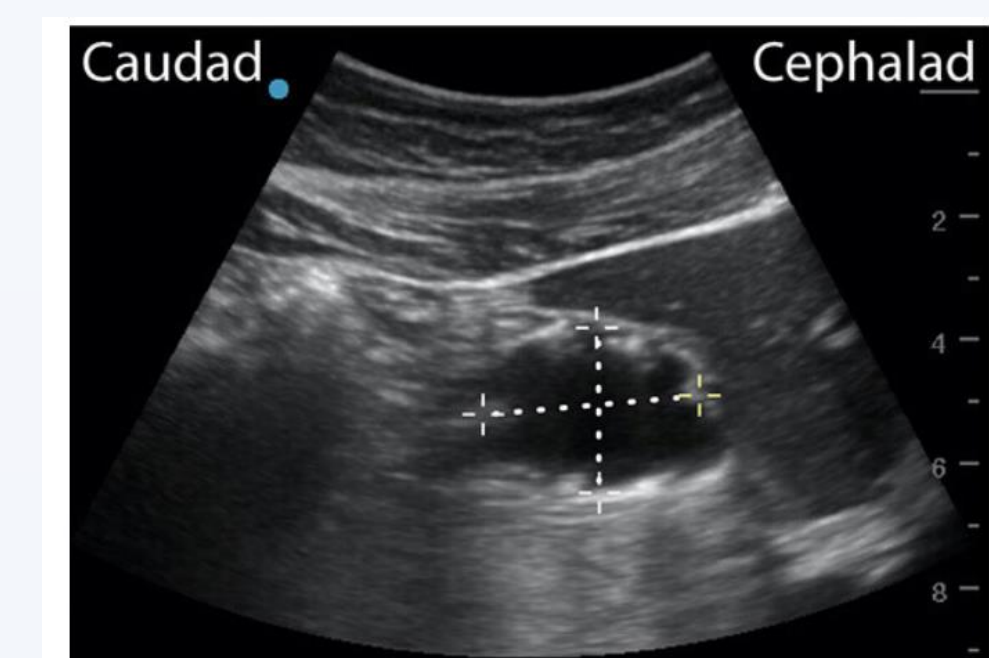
Sonogram Showing Solid in the Antrum with Frosted Glass Appearance in a Sagittal Scan.
